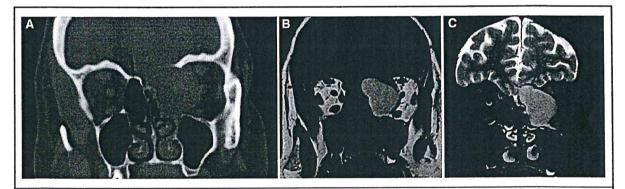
Fifty-year-old male with left proptosis and headache. Left frontoethmoid mucocele. A. Coronal bone algorithm CT shows complete destruction of the left ethmoid roof, and lamina papyrecea, by a soft tissue mass. On the right, note the normal cribriform plate (small arrow) and ethmoid roof (longer arrow). B, Coronal TI MR image shows the mass is well circumscribed and homogeneously high SI. There is a smooth interface with the brain suggesting the dura is intact. Note lateral displacement of the left medial rectus muscle (long arrow) and superior oblique muscle (arrowhead). The mucocele contents are proteinaceous, and therefore high SI on TI MR without contrast. C, Coronal T2 MR with FS shows intact dura laterally as line between mucocele and brain (arrow) is present. More medially the dura is thinned and possibly dehiscent, as the black line is not preserved (small arrow). There is still a smooth interface with the gyrus rectus, and no vasogenic frontal lobe edema.
